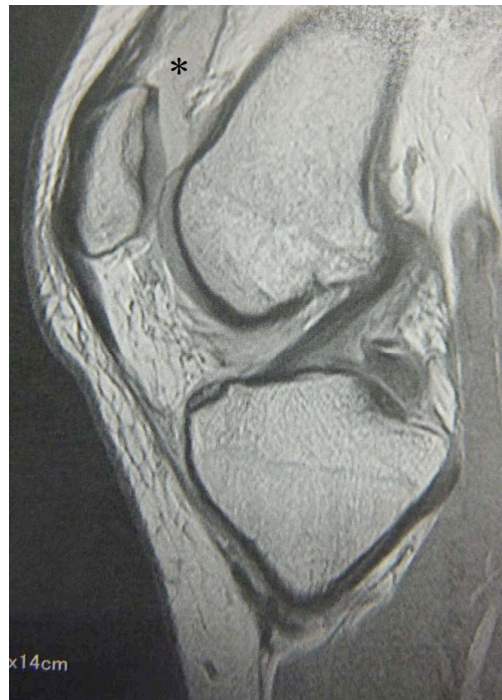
MR image of the knee of a 17-year-old female with a partially torn ACL proven on arthroscopy. This image shows a continuous low signal band of the ACL with the fluid sign. *: hemarthrosis.
